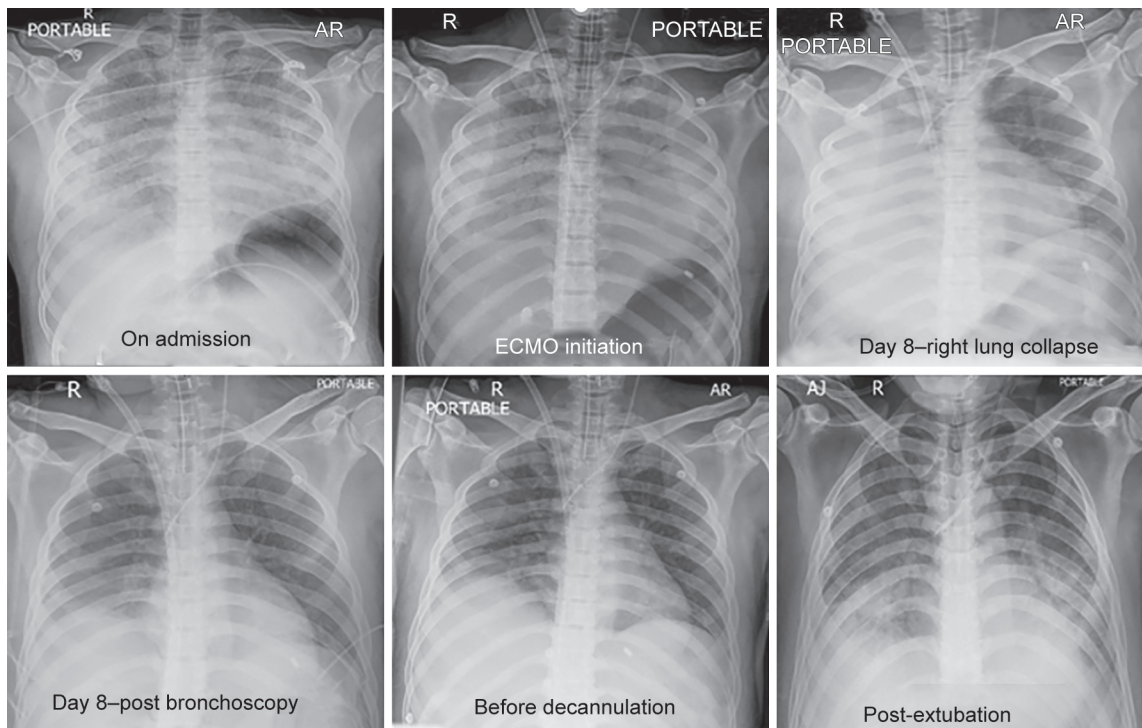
Evolution of chest X-ray in patient 2
